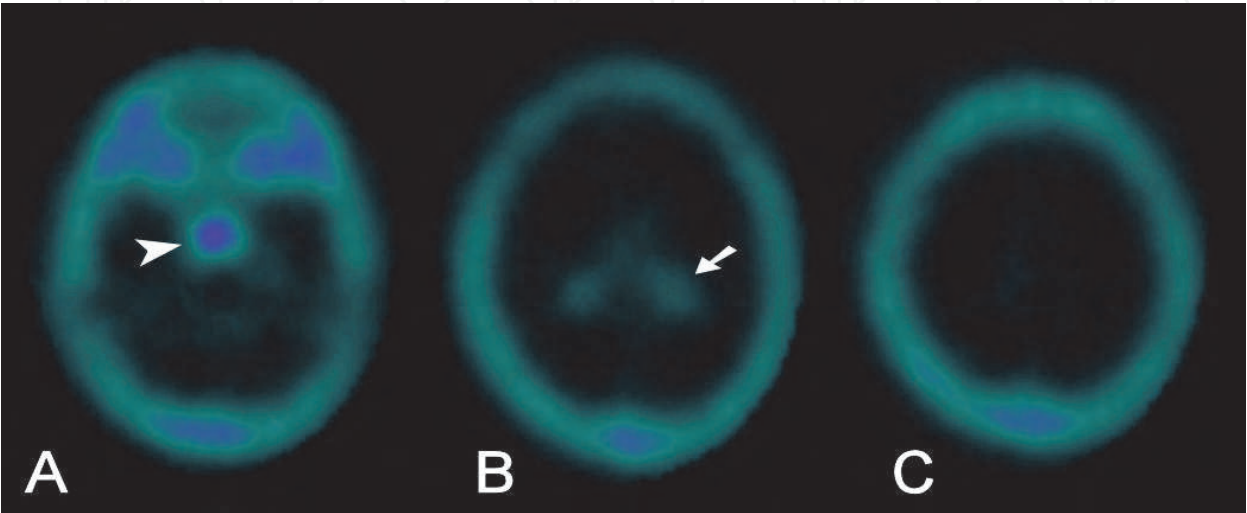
A normal ^{99m}Tc-tetrofosmin brain SPECT study (transversal slicing in three different planes) displaying physiological tracer accumulation in the choroid plexuses (arrow), the pituitary (arrowhead) and the scalp.
